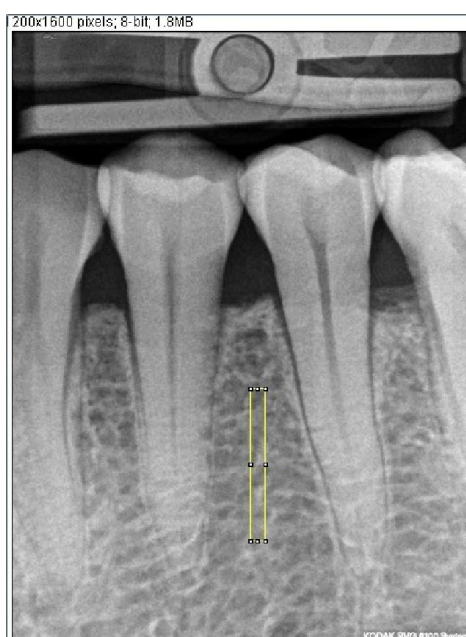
Screen shot of the region of interest measuring about 40 X 400 pixels (the yellow rectangular outline), which is selected on the direct digital intraoral periapical radiograph using ImageJ (1.41v) software
